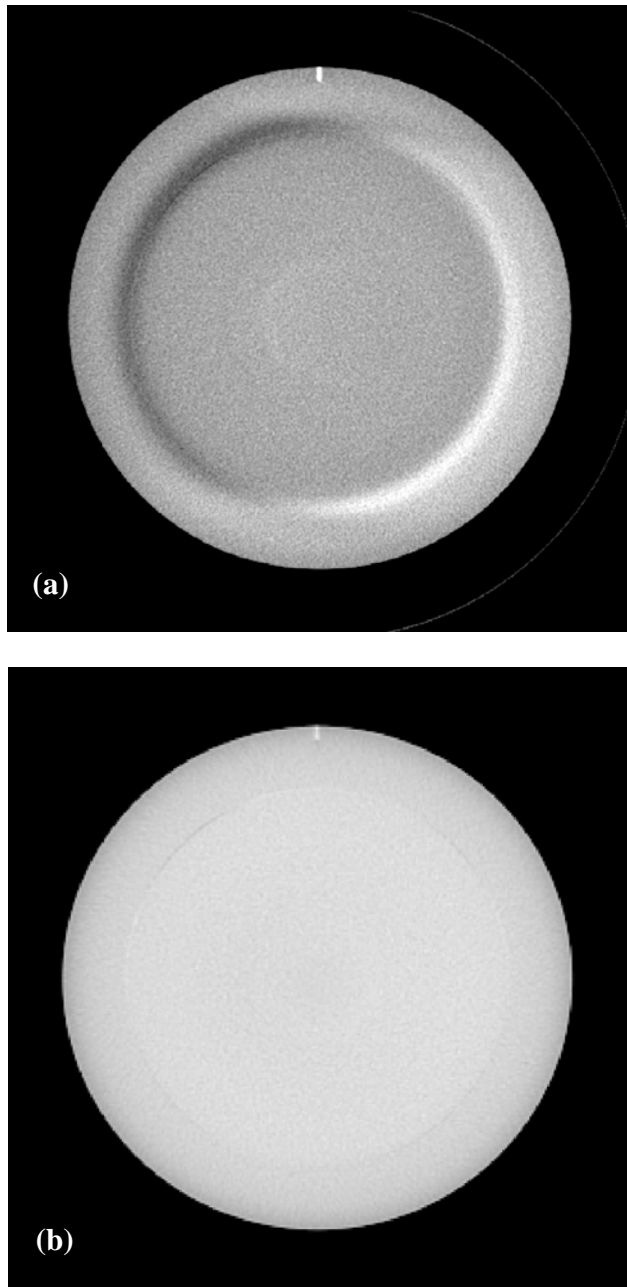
CBCT images for the HU uniformity test obtained from (a) CBHQH (partial-angle scan) and (b) CBPEL (full-angle scan) protocols. Note the crescent effect at the interface of the two different density materials.
